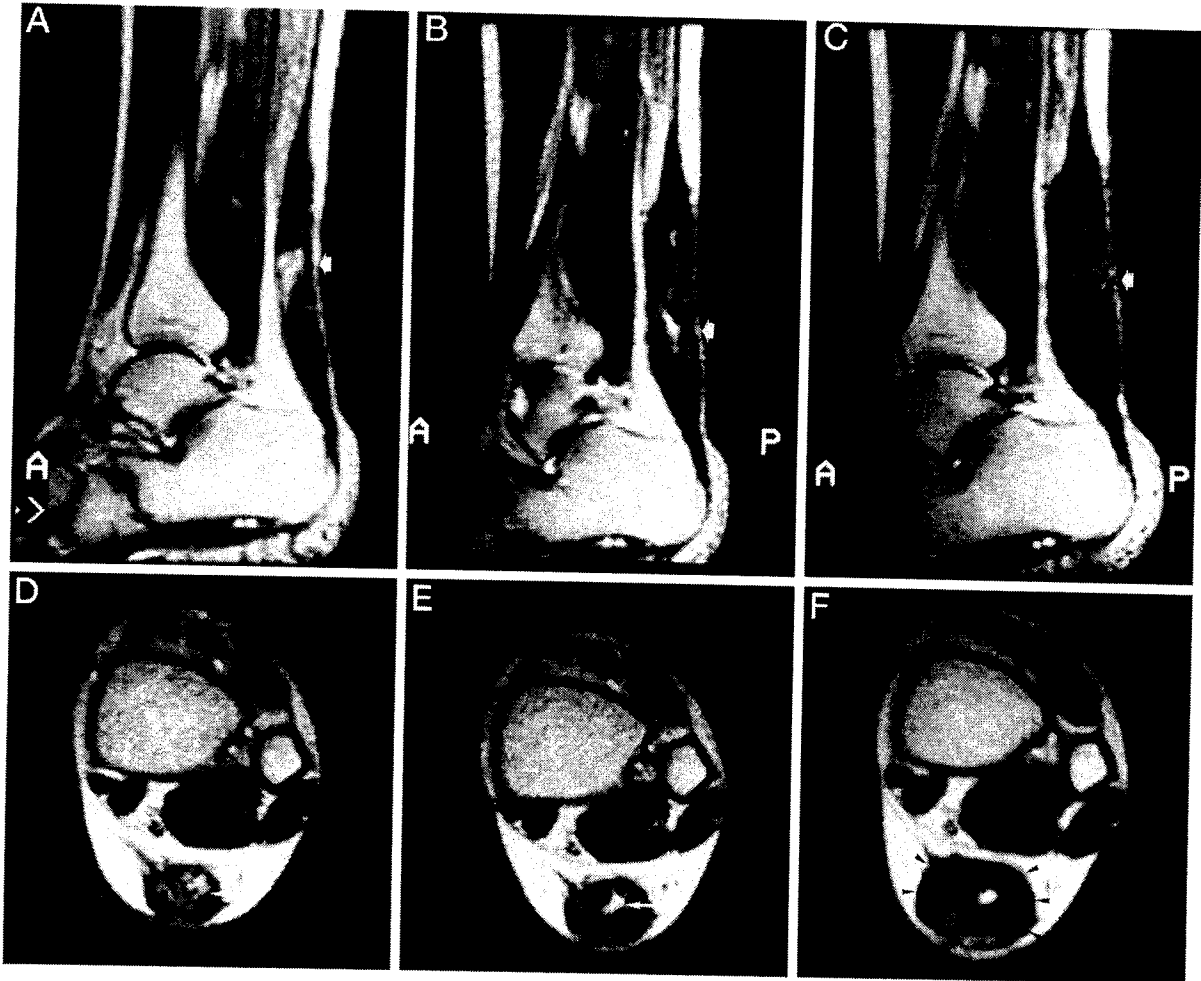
Sagittal T2-weighted MRI scans of the repaired Achilles tendon of patient No. 6 at 5 (A), 8 (B), and 12 (C) weeks after surgery. Axial T2-weighted MRI scans of the repaired tendon in the same patient at 5 (D), 8 (E), and 12 (F) weeks. The high-intensity signal area on sagittal views in the tendon repair site existed at 5 weeks (A, big arrow), changed to intermediate- or high-intensity signal at 8 weeks (B, big arrow), and to low- or intermediate-intensity signal at 12 weeks (C, big arrow). At 18 weeks, the entire tendon became low-intensity signal. On axial views, the high-intensity signal area in the tendon repair site existed at 5 weeks (D, arrow). A small intratendinous high-intensity area persisted at 8 weeks (E, arrow) and was surrounded by a thick low-intensity signal tendon at 12 weeks (F, arrowheads).
